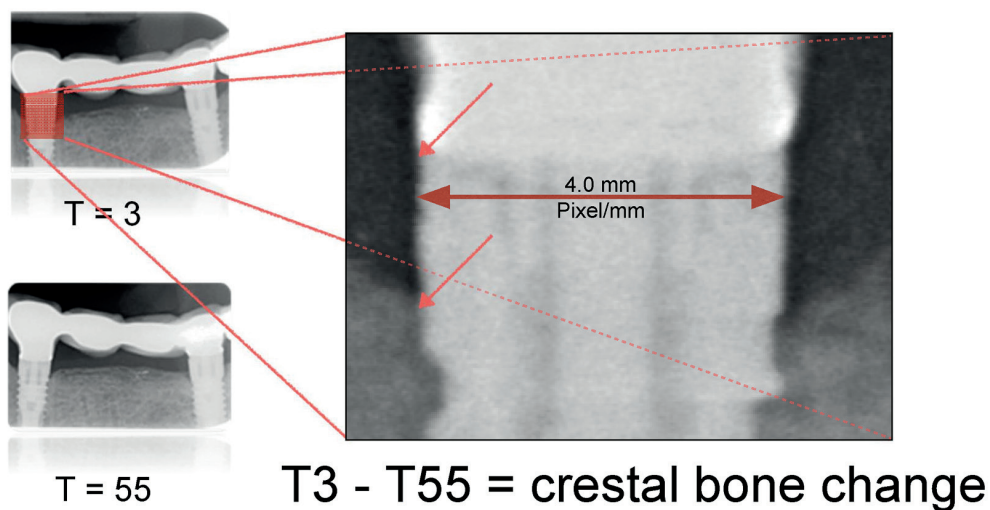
The standardized x-ray was used to obtain the radiographical bone levels.
